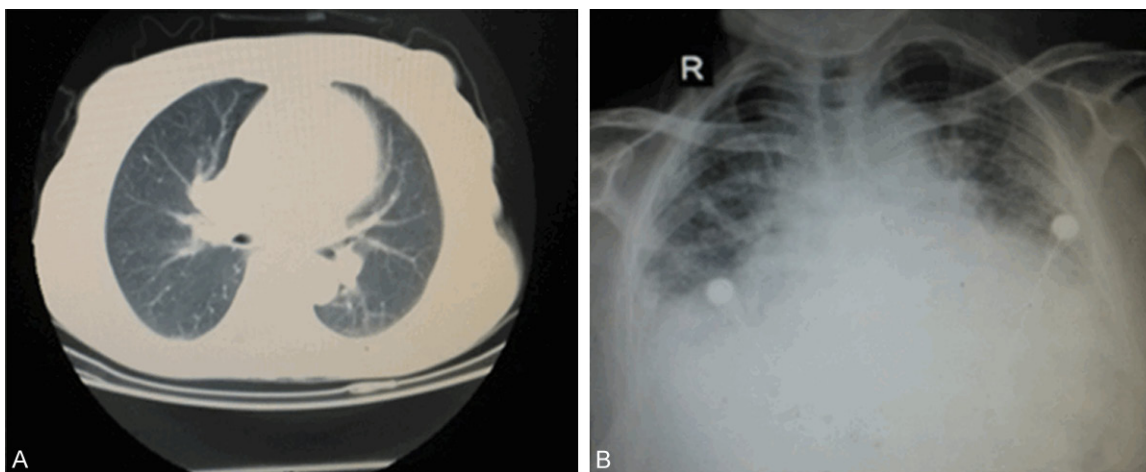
Lung imaging examination before and after bortezomib therapy. A. CT of the chest before bortezomib showed lytic lesions, without obvious pulmonary inflammation. B. X-ray of the chest on day 5 of the first course of bortezomib showed bilateral pulmonary infection with bilateral pleural effusion, aorta widened and increased heart shadow.
